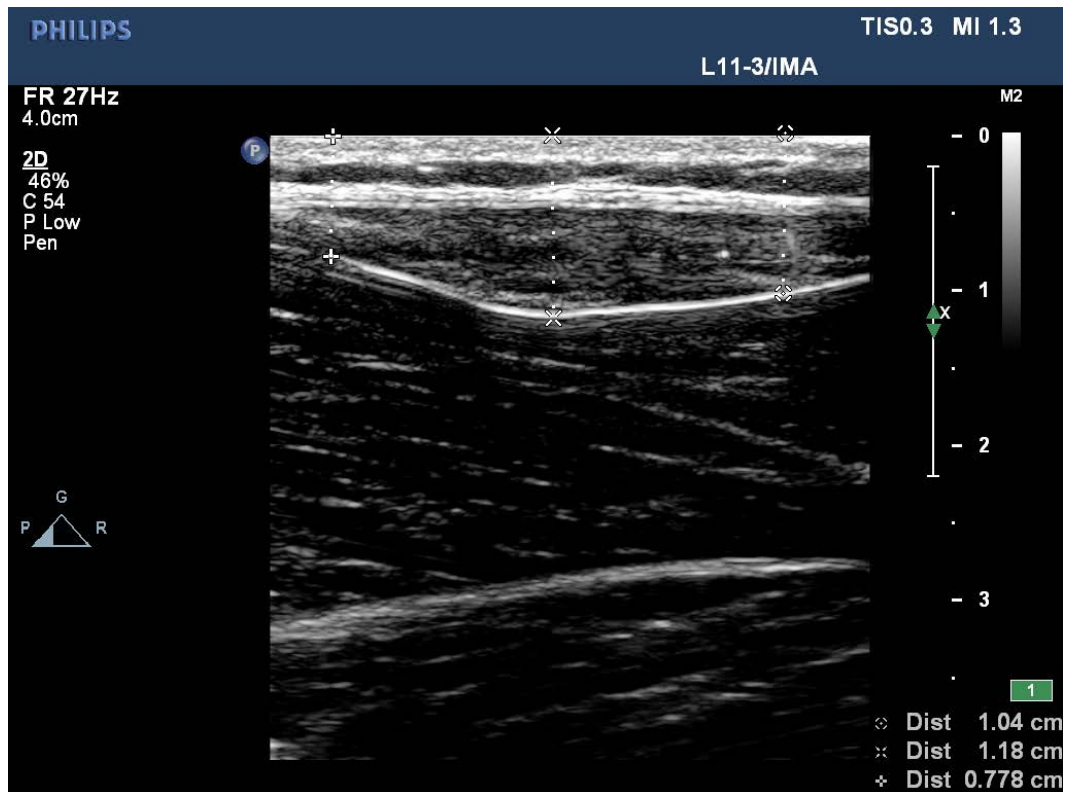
Representative ultrasound image of the temperature probe within the vastus lateralis
